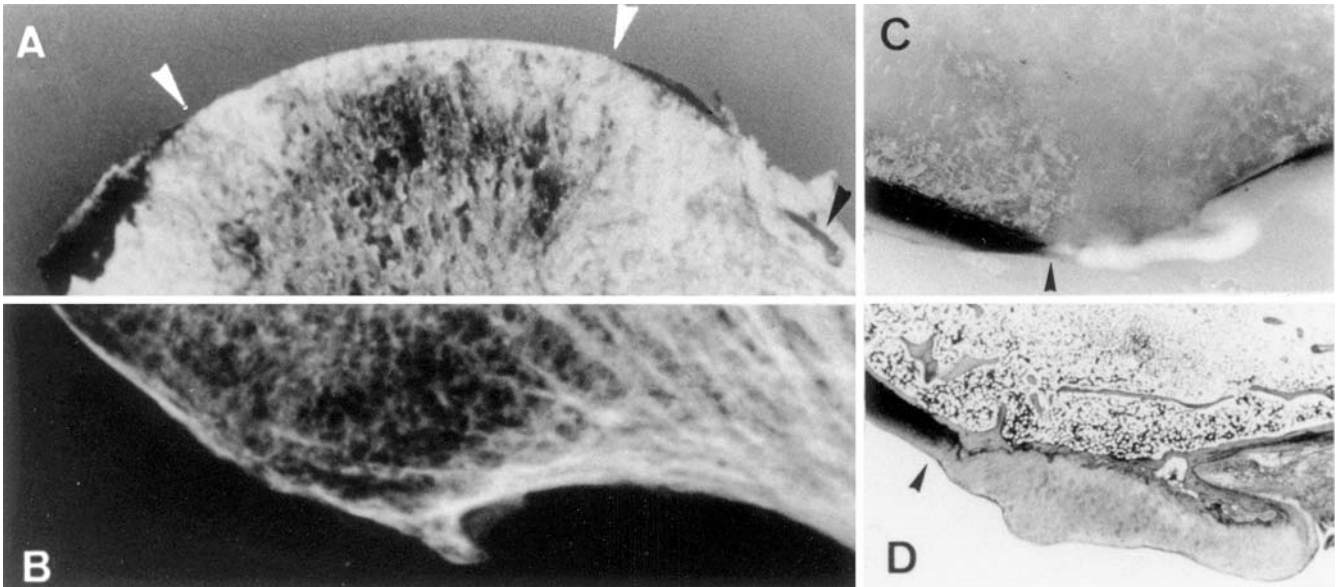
Two essential territories in an ochronotic femoral head with remodelling of the OA type. On the *left*, medial part. For X-rays of femoral head and hip joint, see Refs. [24, 25]. a Between two *white arrowheads*, weight-bearing area with eburnated denuded bone and underlying osteomedullar remodelling in which pigmented cartilage shards are embedded. Medial and lateral remnants of ochronotic cartilage cover. Embedding of a cartilage fragment in hyperplastic synovial membrane (*black arrowhead*); macroscopical slice $\times 2.5$.
